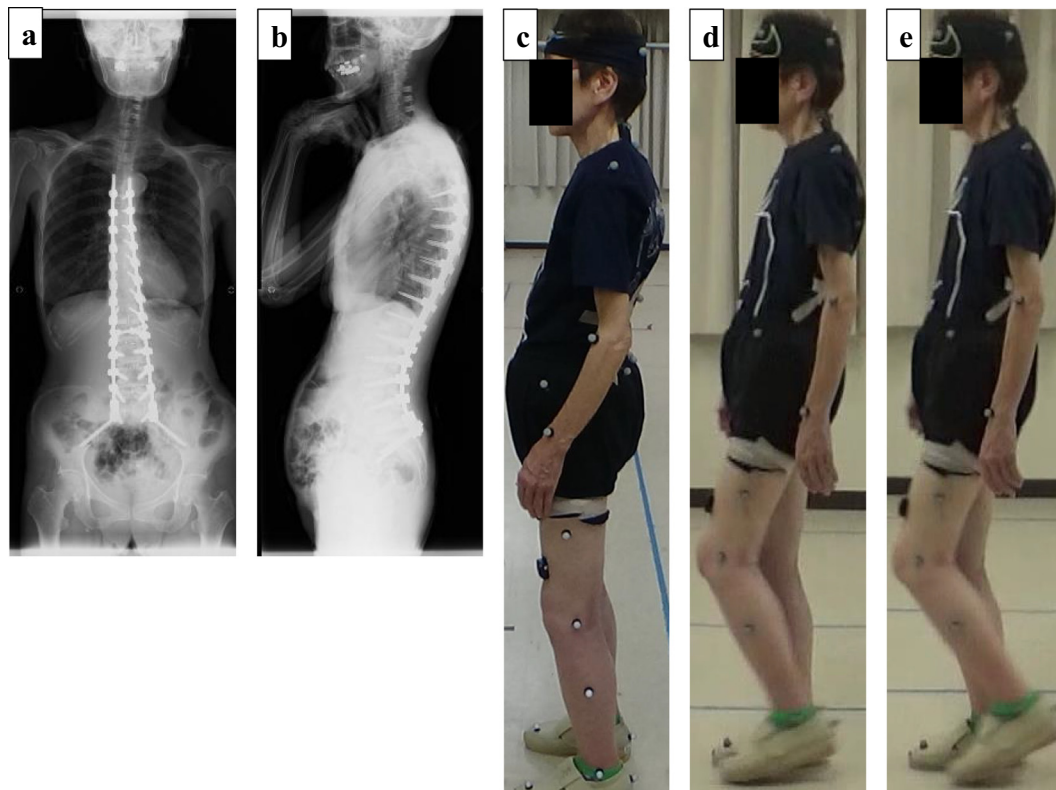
Postoperative radiographs and posture: (a, b) Whole spine radiograph showing good correction of the spinal kyphotic deformity. (c) Lateral posture on standing. (d) Lateral posture during gait analysis immediately after the start of walking. (e) Lateral posture during gait analysis just before the patient finished walking showing preservation of her corrected posture.
